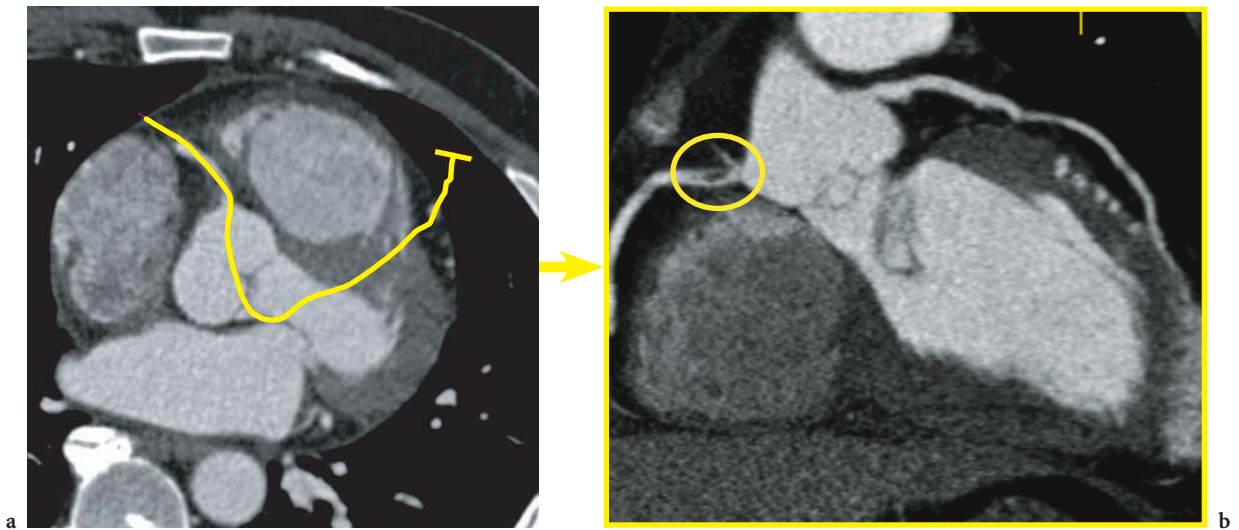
Curved MPR for a coronary artery examination obtained on a 64-slice CT scanner. a The yellow line in the axial image indicates the curved image plane of the MPR, which has been generated manually by the user, with interactive placement markers in the vessel based on the axial slices. b The curved MPRs can be used to follow the course of a tortuous coronary artery along its entire length and reveals a high-grade stenosis in the proximal RCA (*yellow circle*). (Case courtesy of Erlangen University, Germany)
